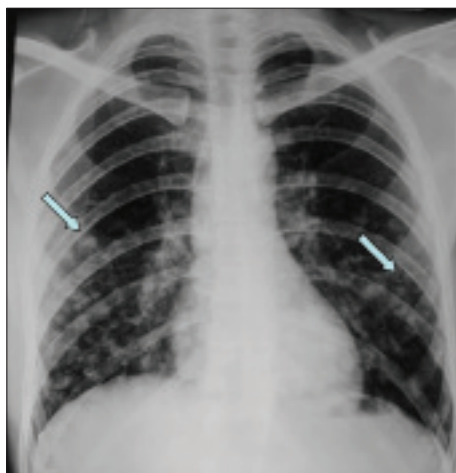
X-ray chest showing nodular opacities in both lungs
